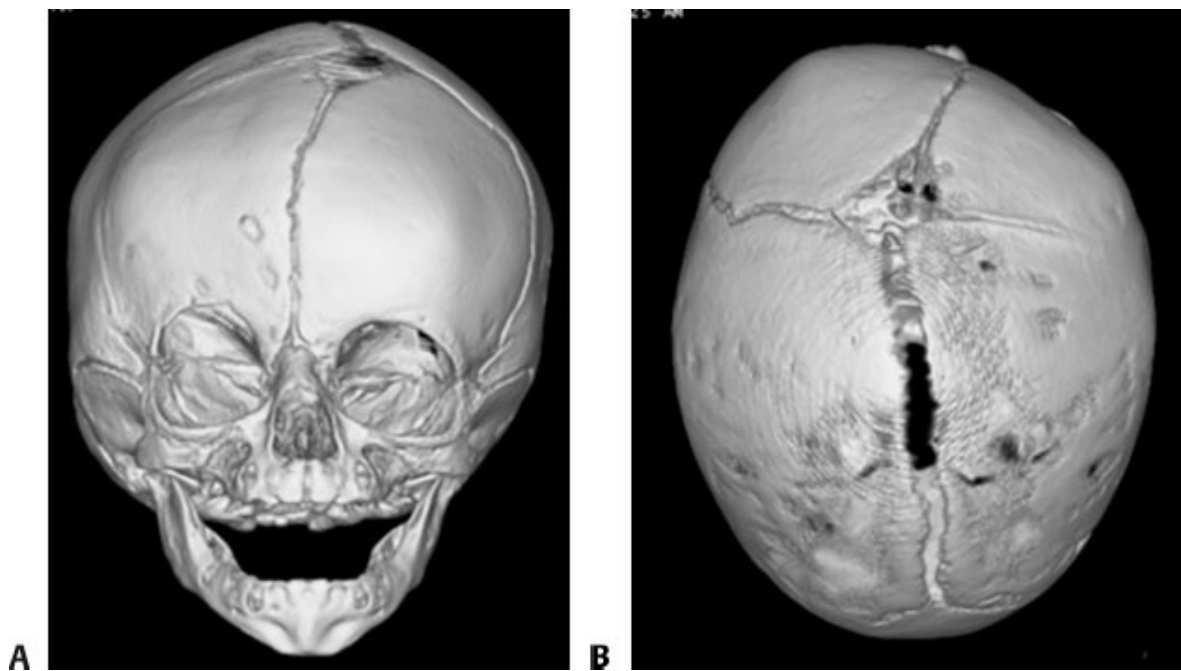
• 3D CT scans of the same female infant with right unicoronal synostosis.
